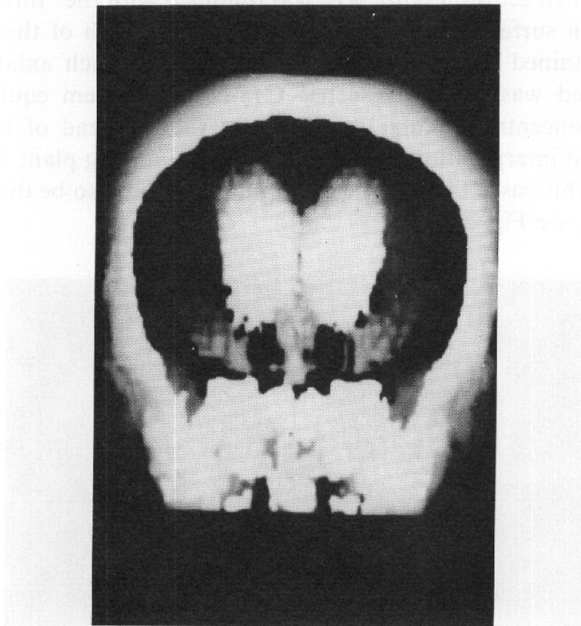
3-D image of ventricles using "thresholding" of very low CT numbers.
